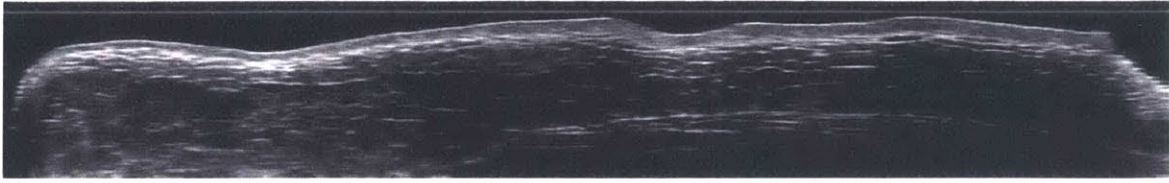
Ultrasound image along the plane measured with calipers
